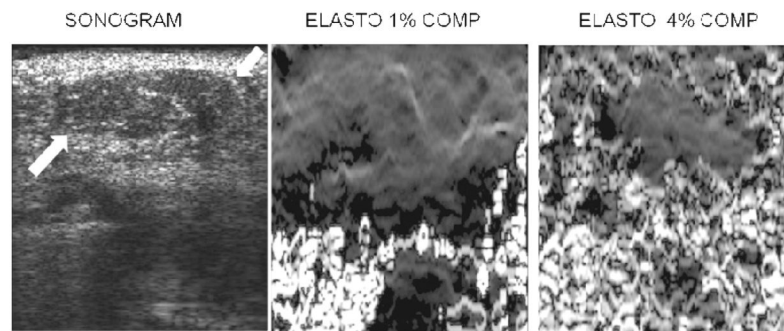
Sonogram (left image), 1% compression elastogram (middle) and 4% compression elastogram (right) of a fibroadenoma (arrows on sonogram). Note that the fibroadenoma is not really visible on the 1% compression elastogram but is visible as an area without decorrelation noise on the 4% compression elastogram. The 1% elastogram has less decorrelation noise than the 4% elastogram but a lesion may be more visible on the “noisier” elastogram.
